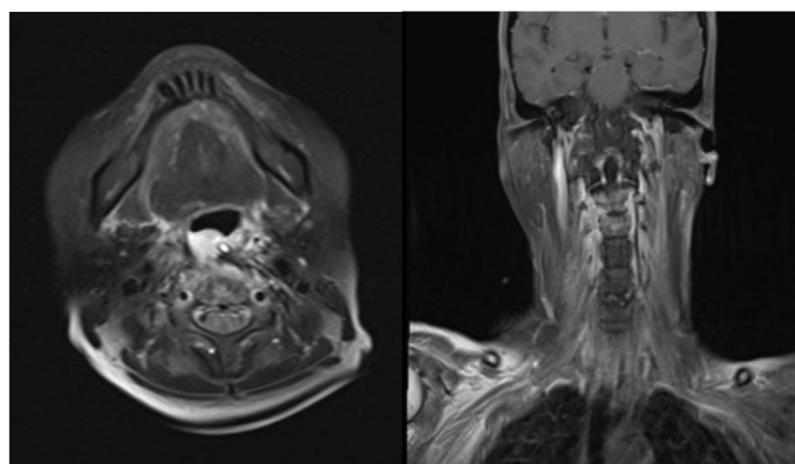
MRI Images of patient 8 weeks post TORS Left: Enhancing soft tissue mass on right posterior oropharynx, T2 weighted axial MRI; Right: Abnormal marrow signal of C2 and C3, T1 weighted coronal MRI.
